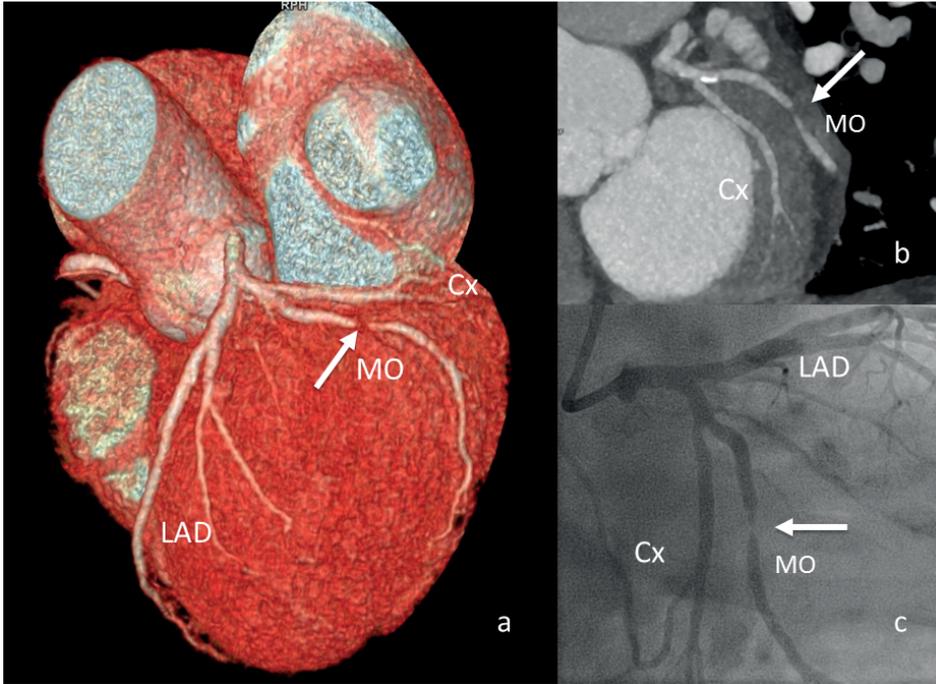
Severe coronary stenosis. CT shows a severe stenosis of a large obtuse-marginal branch (MO) of >70% (arrow). Maximum intensity projection of the circumflex artery (Cx) and the MO showing the severe stenosis (arrow) (b). Invasive angiography showing the left coronary system and stenosis (arrow)(c).
